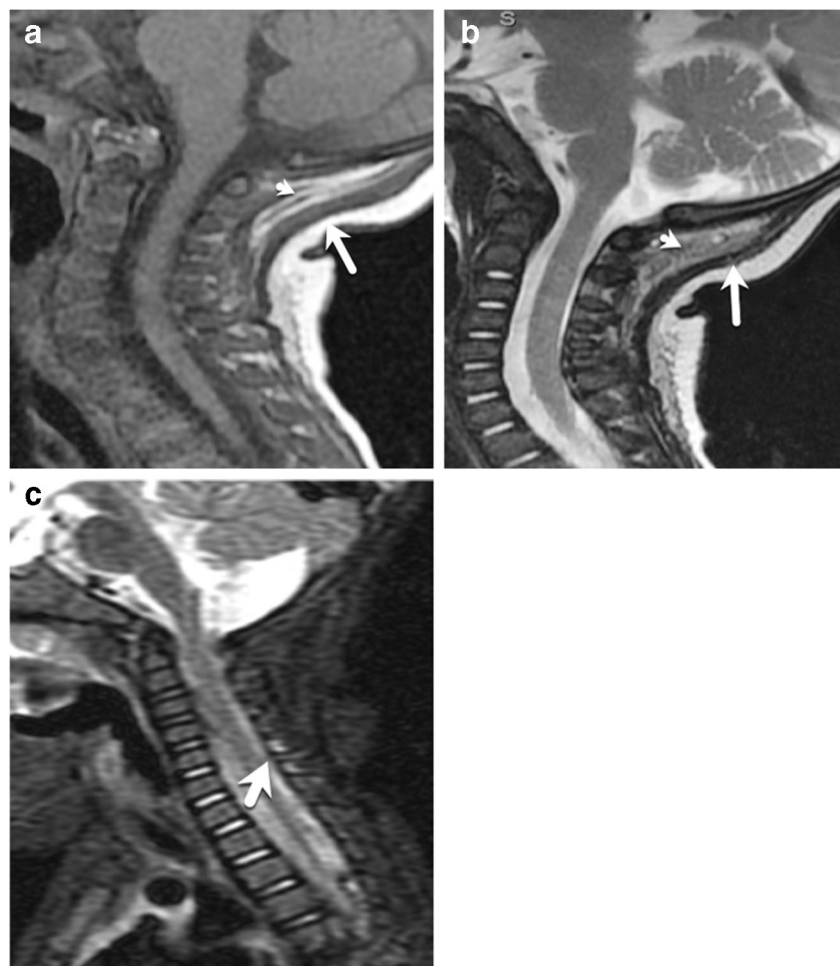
Abusive head trauma (AHT) in a 3-month-old boy. a Initial presentation of this boy was with seizure at 3 months of age. Sagittal T1-W MRI of the cervical spine demonstrates a normal nuchal ligament and suboccipital soft-tissue structures. b His second presentation, at 5 months of age, with AHT. Sagittal T1-W MR image of the cervical spine demonstrates stranding of the fat in the region of lamellar membrane of the nuchal ligament and swelling of the funicular segment of the nuchal ligament (*long solid arrow*). Hyperintense subdural hemorrhage is identified in the supratentorial compartment (*dashed*
